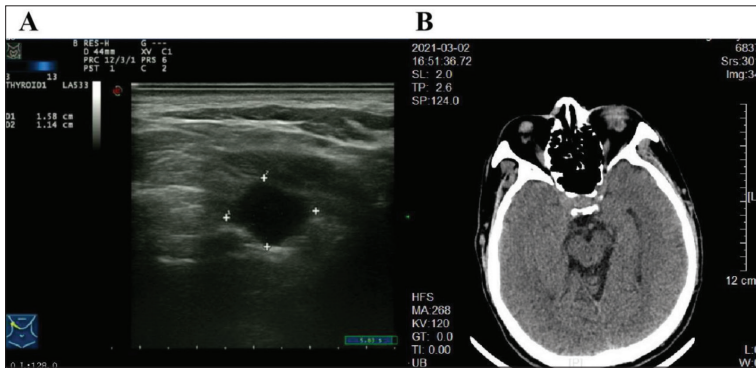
Ultrasound image analysis and computed tomography (CT) scan; A – abundant blood flow signals observed in ocular nodules via conventional ultrasound; B – orbital CT scan showed a lesion in the right lower fornix
